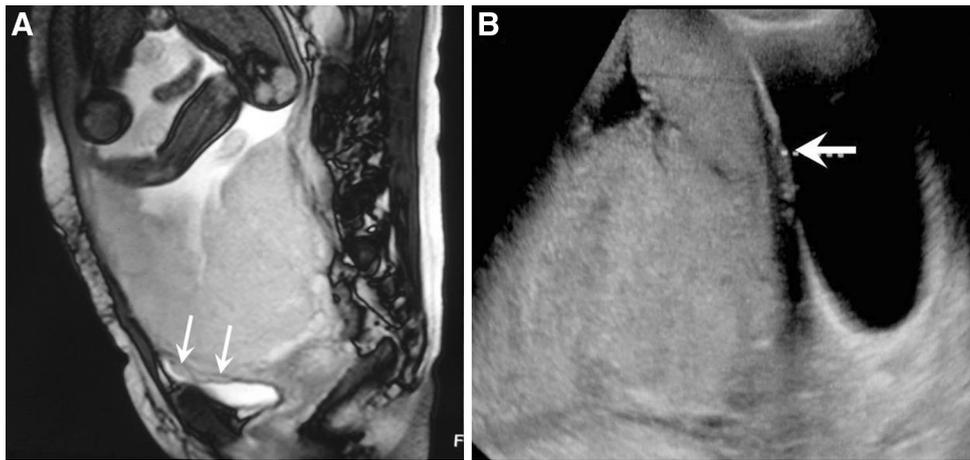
Patient 2. a Sagittal and b Coronal MRI shows maintained bladder-myometrial interface with a completely maintained India ink line (*arrows*), in spite of a heterogeneous placental intensity, abnormal uterine bulging and multiple dark heterogeneous bands. MRI diagnosis of placenta accreta without bladder invasion was given. *Color Doppler* revealed central placenta previa with placenta accreta
